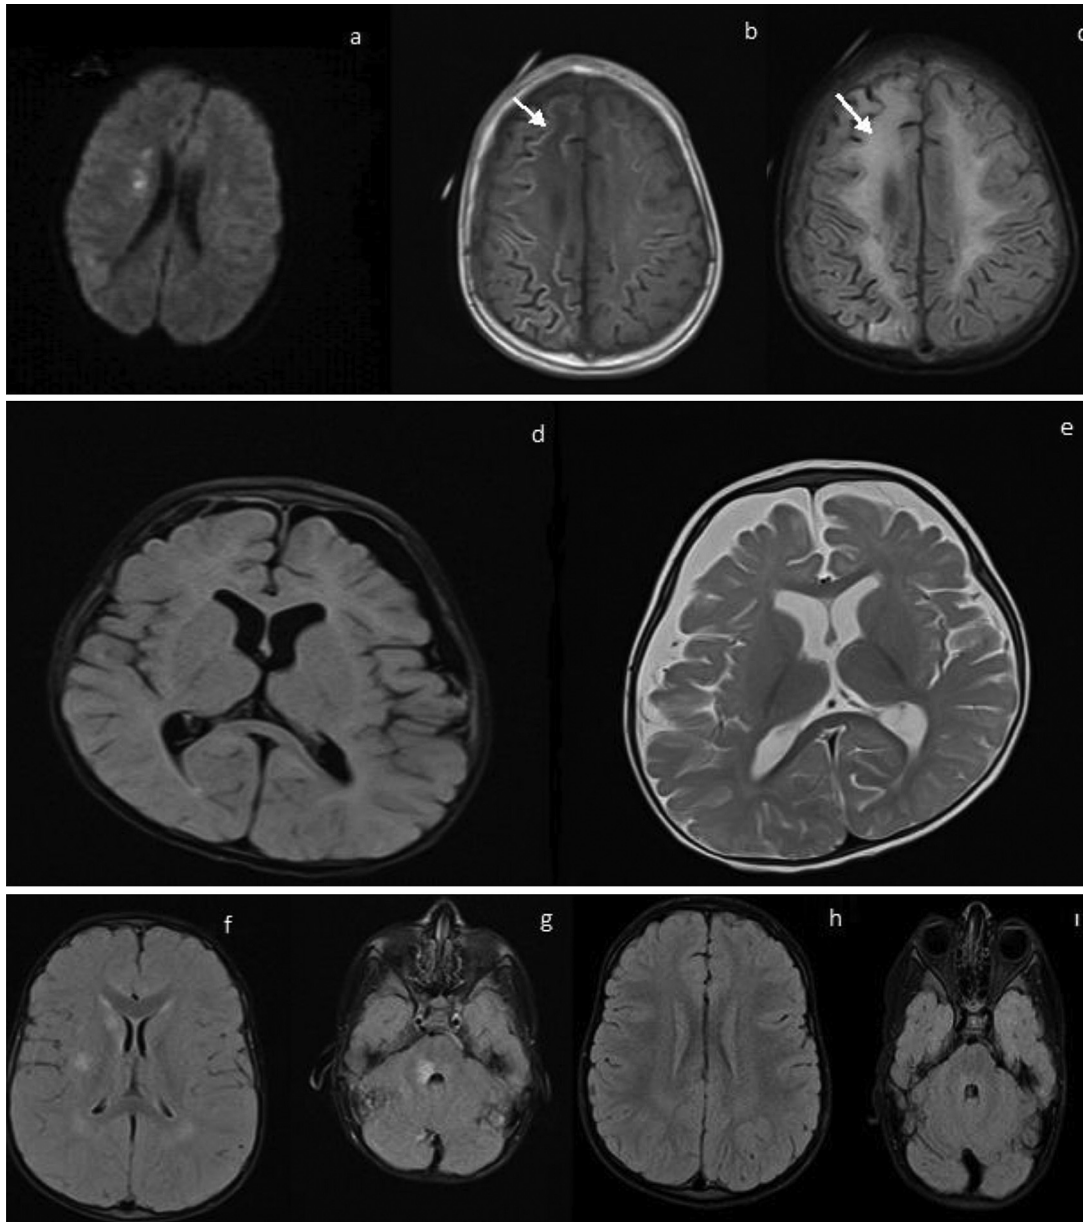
Brain magnetic resonance imaging of children. (A) Acute phase of patient 1; showed cortical and subcortical signal increase in T1-weighted sequences in both cerebral hemispheres. (B, C) Subacute phase of patient 1; showed laminar necrosis (arrows) and gliosis in T1-weighted and fluid-attenuated inversion recovery (FLAIR) sequences. (D, E) T1- and T2-weighted axial images; first and follow-up MRI of patient 2; atrophy in the left hemisphere was interpreted as a sequela change. (F, G) Acute phase of patient 3; showed cortical and subcortical signal increase in FLAIR sequences in both cerebral hemispheres and brainstem. (H, I) Follow-up MRI of patient 2; normal.
